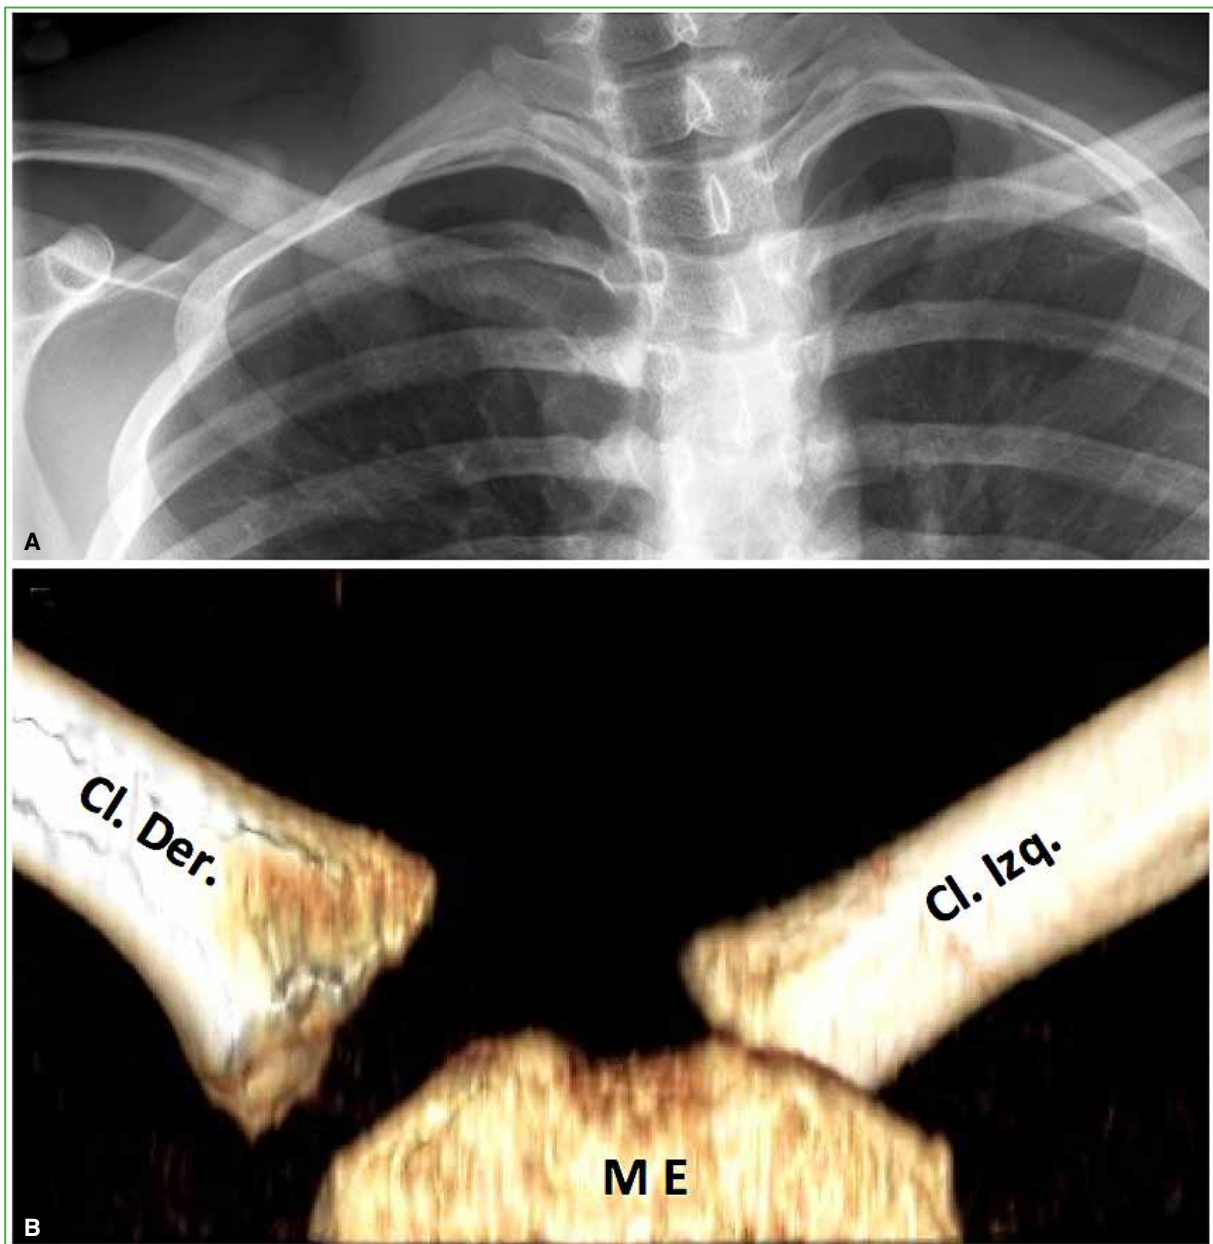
A. Chest radiograph, anteroposterior view. May be suggestive but is not conclusive. B. CT of both sternoclavicular joints with 3-D reconstruction, anterior view, showing posterior dislocation of the left sternoclavicular joint. ME = sternal manubrium; Cl Rt = right clavicle; Cl Lt = left clavicle.
